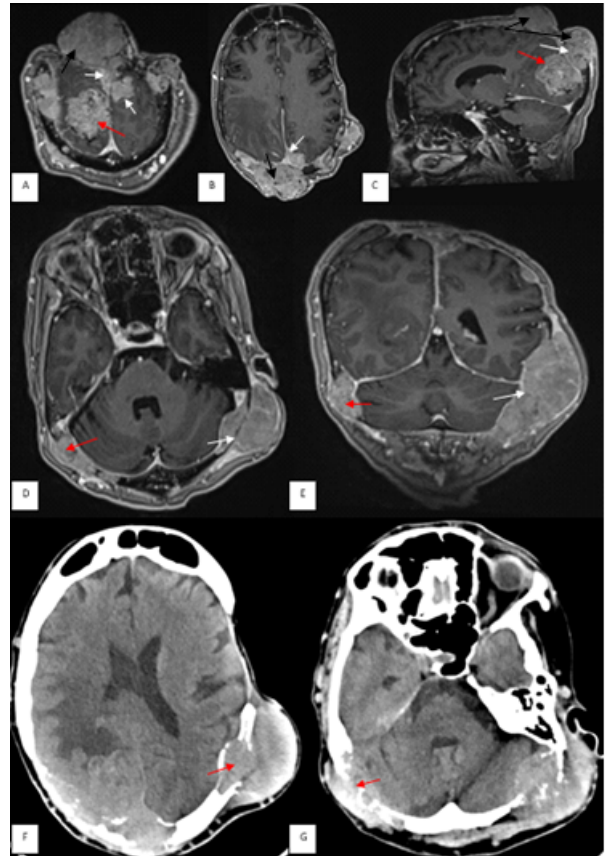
(A-E) The last follow-up MR images demonstrating multiple obviously enhancing skull bone and cerebral metastases. Coronal (A), axial (B) and sagittal (C) postcontrast MR images showing the right occipital parenchymal metastasis which is 4 cm in diameter (A, C; red arrows). Multiple extraaxial dural based metastasis are shown (A, B, C; white arrows). 51x37 mm and 55x34 mm sized posterior parietal (A, B, C; black arrows), 45x20 mm sized right occipital (D, E; red arrows) and 95x50 mm sized left occipital (D, E; white arrows) metastases invading the transverse sinuses are shown. F, G) Axial CT images showing lytic and expansile behaviour of the skull metastases (F, G; arrows)
